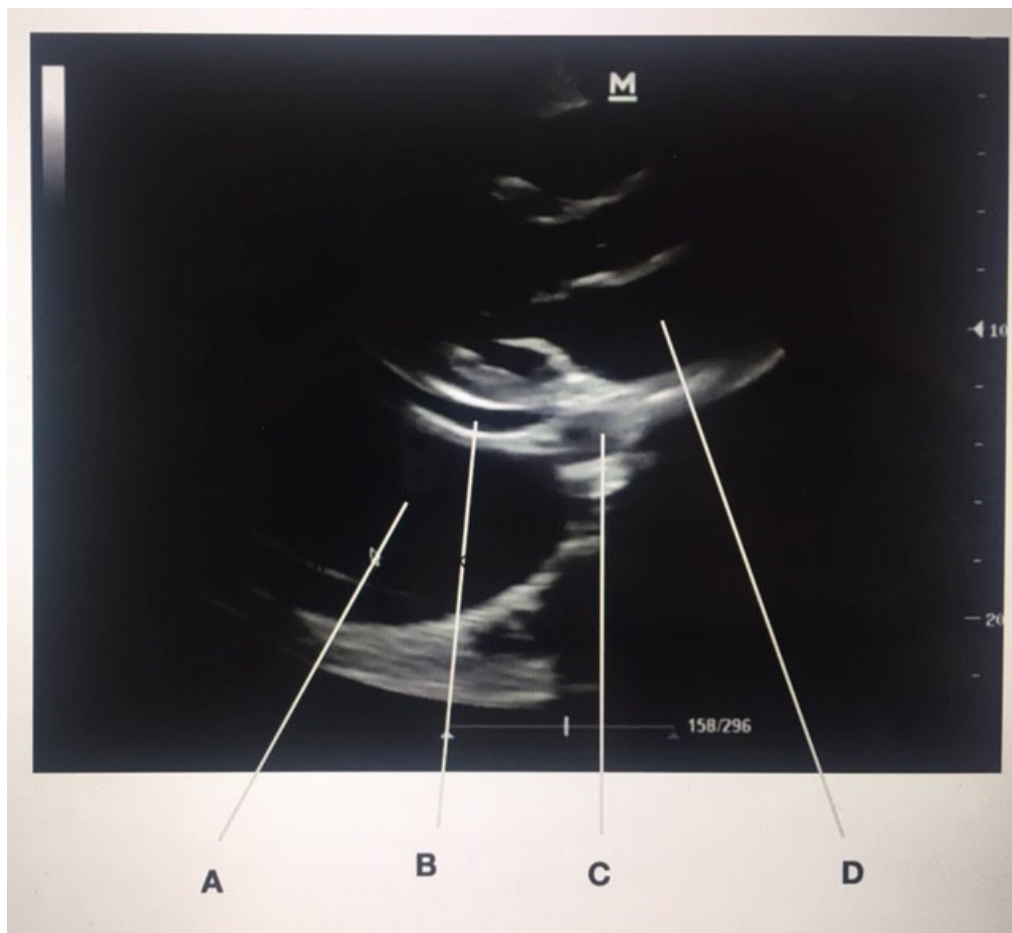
Parasternal Long View
